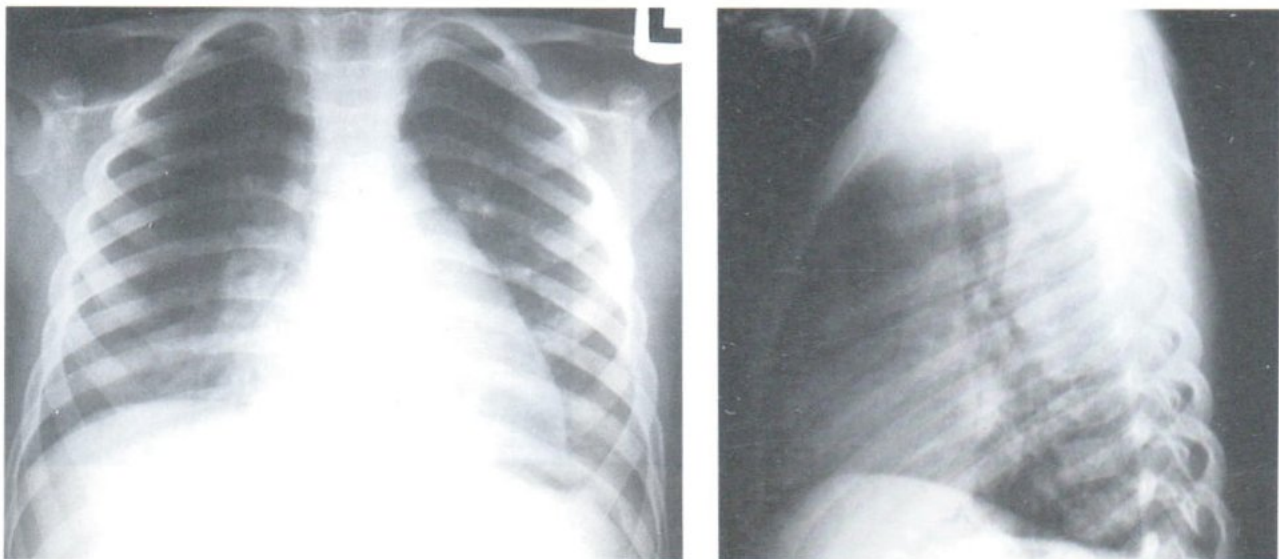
A 2 year old boy with high fever and cough for 3 weeks. PA and lateral chest radiographs show patchy infiltration in right peri-hilar area, RML, and both lower lobes. Rt. hilar adenopathy is noted.
